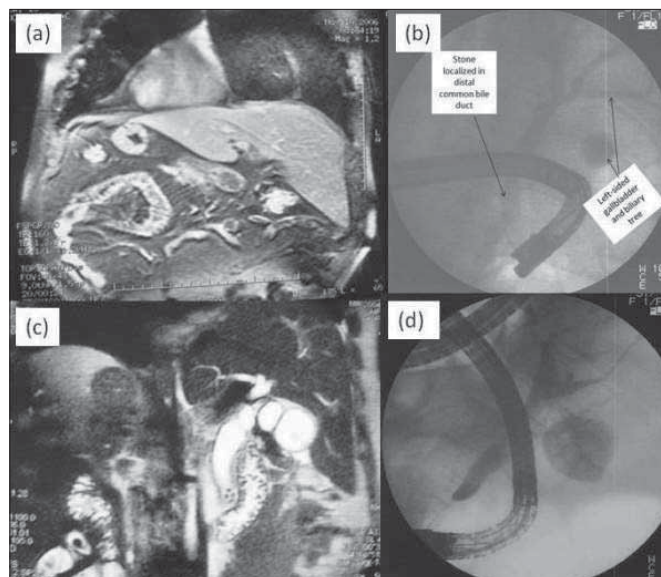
(a): MR imaging of left-sided position of the liver (b): ERCP imaging of the left-sided position of gallbladder and biliary tree (c): MR imaging stones in left-sided distal common bile duct (d): ERCP image demonstrating the "long scope position" of the duodenoscope and filling defects indicating stones in gallbladder
